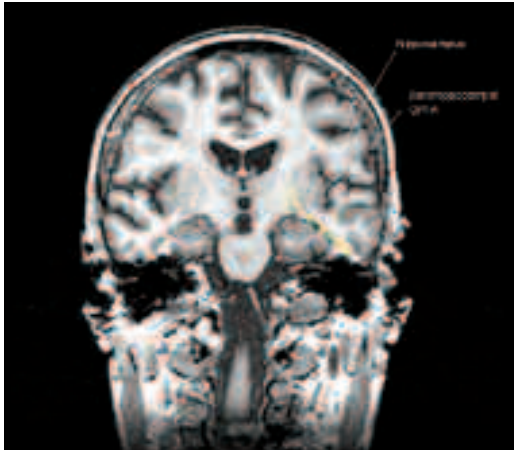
MRI scan showing the location of the hippocampus and parahippocampal gyrus in the medial temporal lobes. These areas are crucial for the processing of declarative memories.
